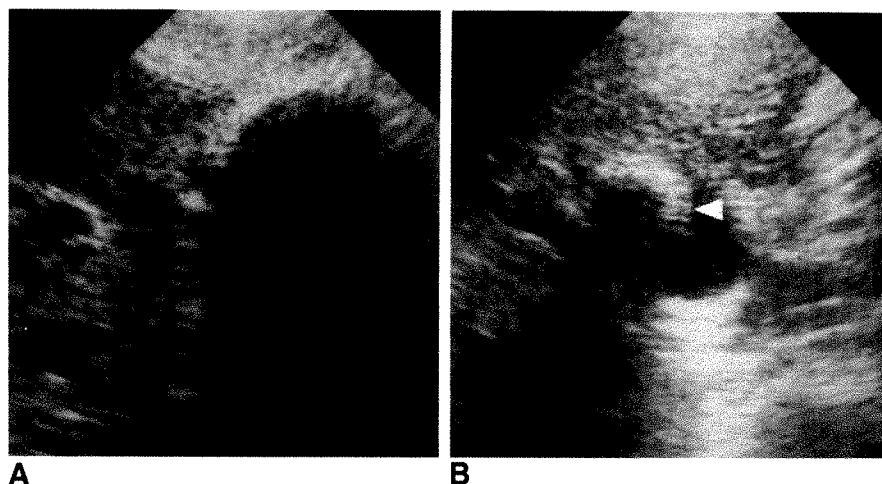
A and B, Preoperative sagittal (A) and transverse (B) sonograms show a shadowing, curvilinear echo within gallbladder fossa without visualization of gallbladder lumen. Although gallbladder is filled with innumerable small calculi, their number and size cannot be discerned.
